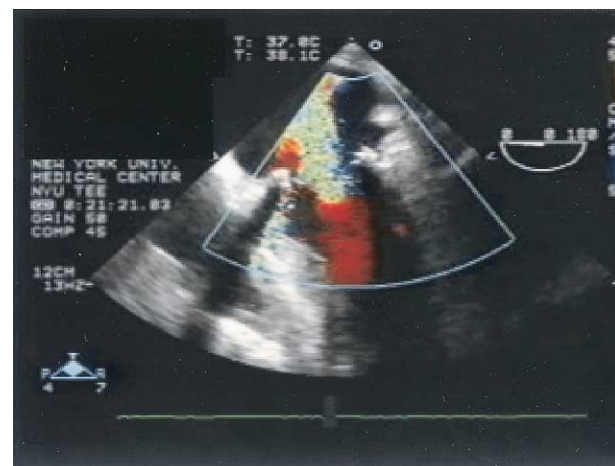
Intraoperative TEE frame with color Doppler after placement of second valve prosthesis. Massive central insufficiency is noted.
